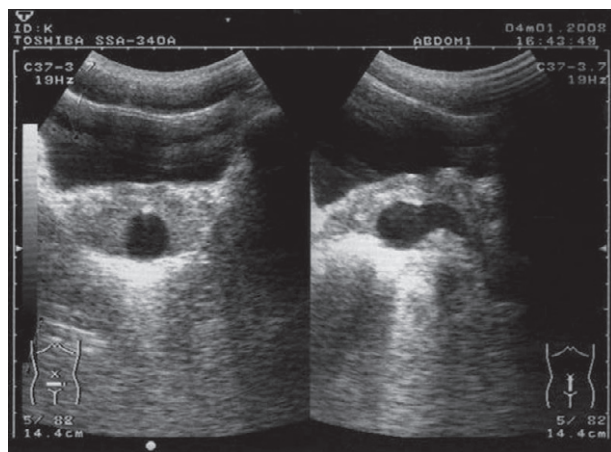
Ultrasonogram shows a cystic-like lesion on the midline of the prostate.
